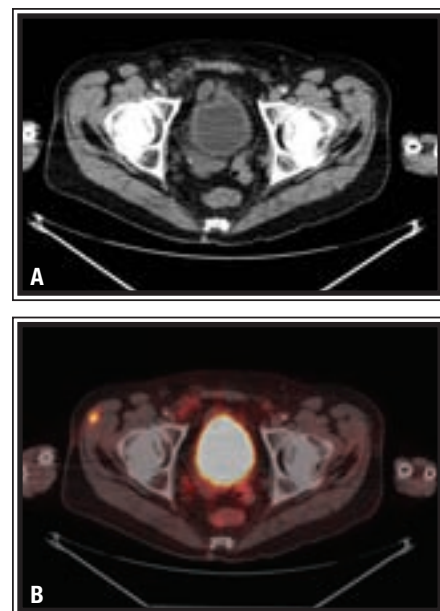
44-year-old man with history of melanoma. Clinical exam was negative. A: Axial CT image shows no appreciable abnormality. B: PET/CT shows distinct intramuscular focal uptake consistent with metastatic nodule.
